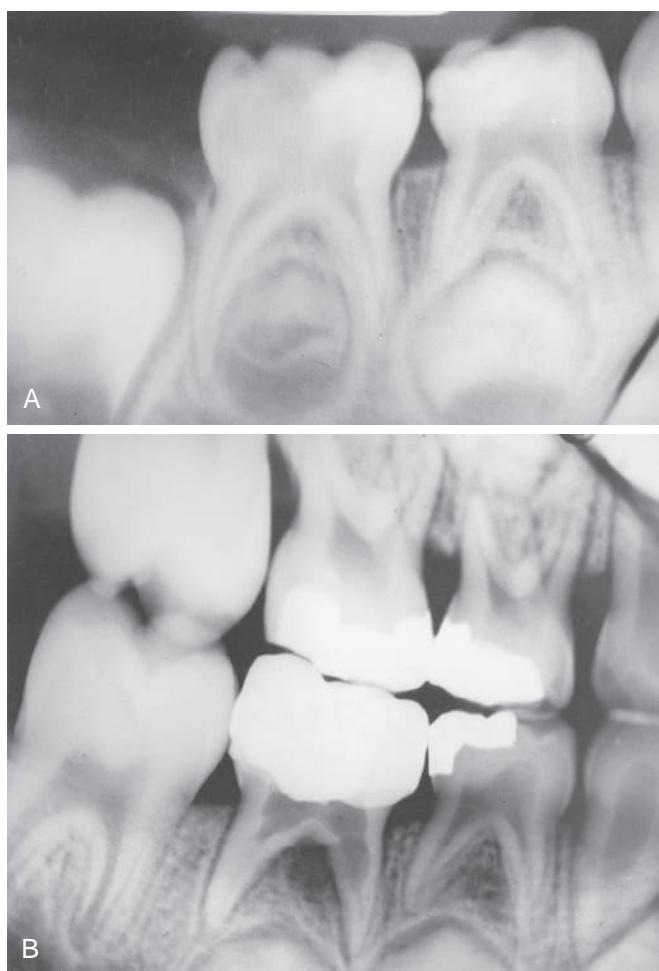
(A) Preoperative radiograph of a second primary molar treated with the calcium hydroxide pulpotomy technique. (B) Two years after treatment, internal resorption and bone rarefaction are evident. (C) There may have been inflammation of the pulp apical to the amputation site and beginning internal resorption at the time of the initial treatment.
